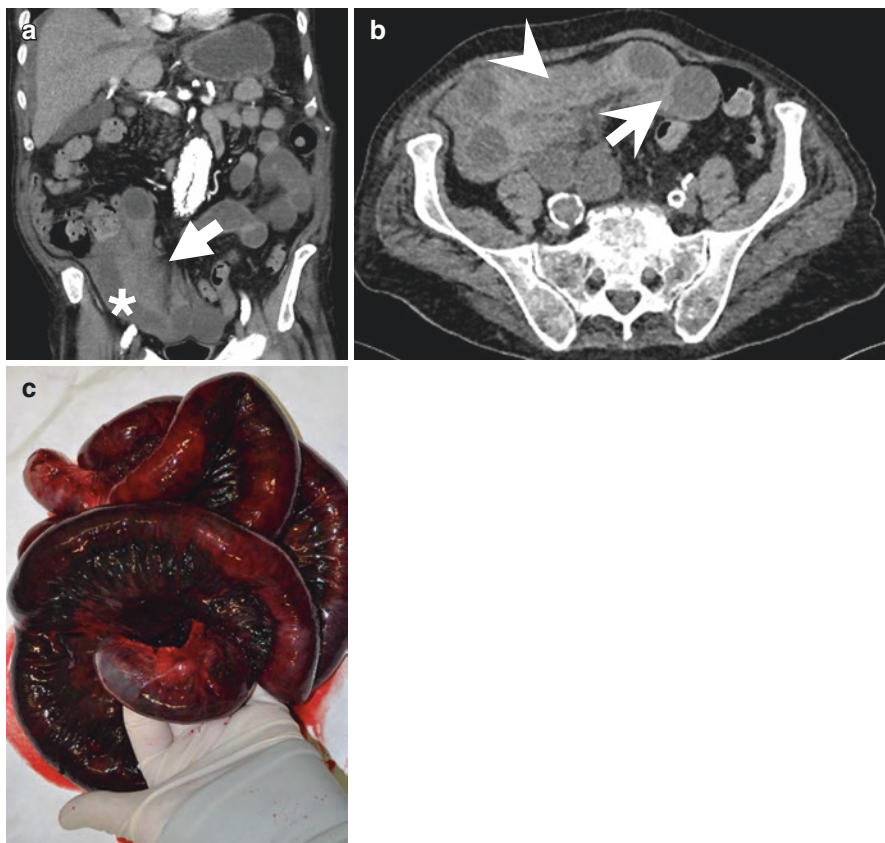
A 55-year-old male with acute abdominal pain and bilious vomiting. (a) Coronal CT shows a strangulated small bowel internal hernia. Focally dilated loops of small bowel (*asterisk*) in the right flank are consistent with a closed loop bowel obstruction. Bowel wall thickening and adjacent mesenteric edema is noted (*arrow*). (b) Non-contrast axial CT demonstrates increased density of the bowel wall (*arrow*) and mesentery (*arrowhead*) suspicious for hemorrhagic infarction. (c) Intraoperative image of the resected small bowel, demonstrating diffuse small bowel ischemia
